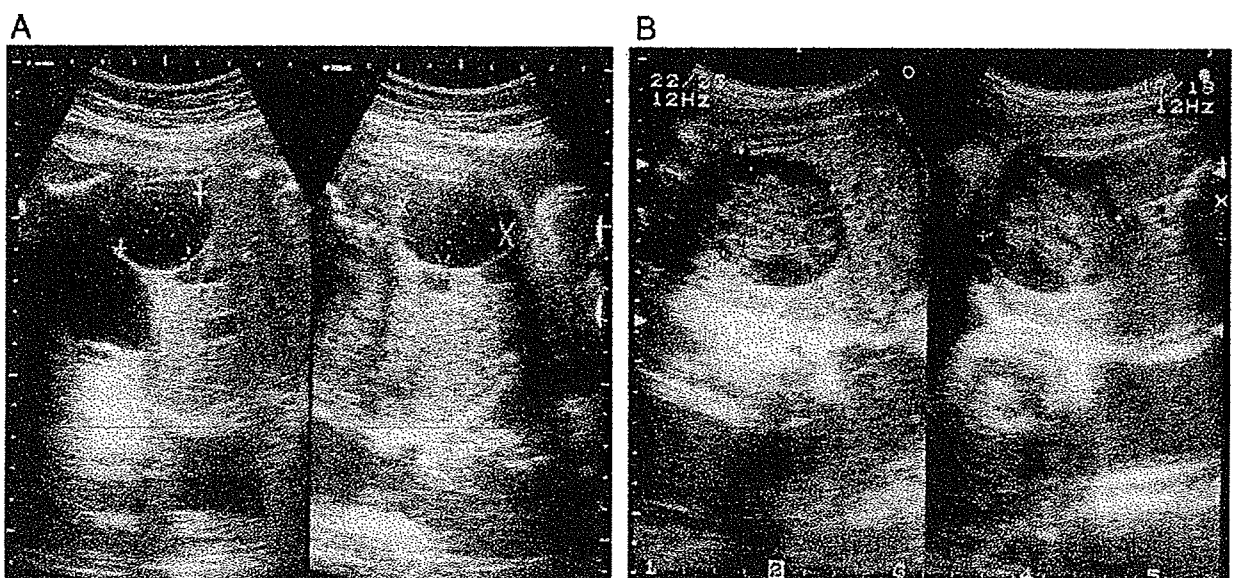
Fetal cystic tumors identified by ultrasonography in the third trimester. (A) A representative example of a simple cyst. The cyst was completely anechoic. Note the surrounding thin wall. (B) A representative example of an echogenic complex cyst.
